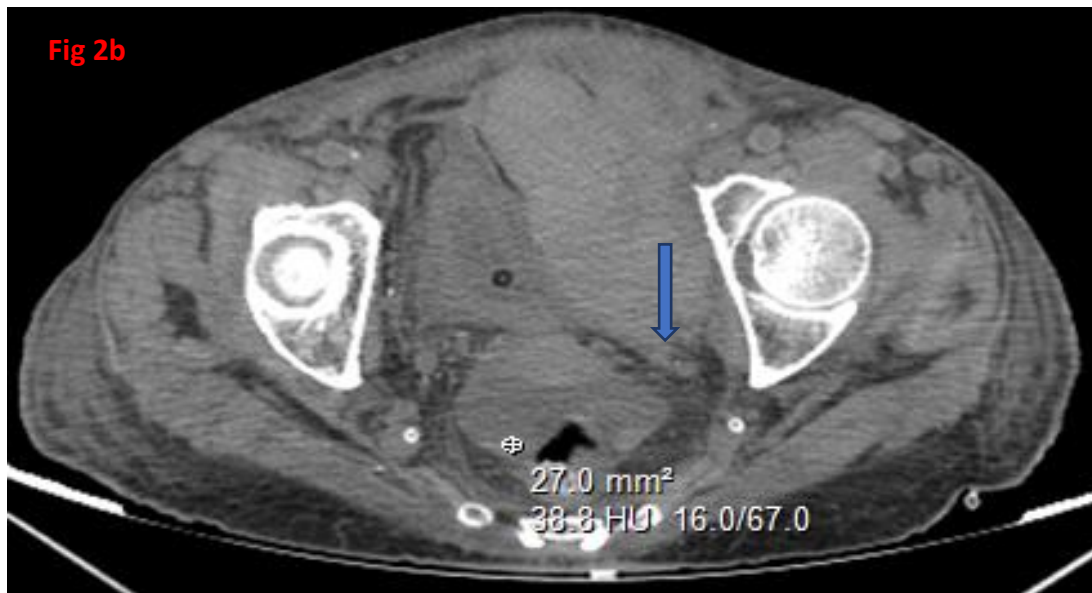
Abdomin-pelvic CT scan: cross section view: showing a moderate hematic peritoneal effusion (blue arrow)
